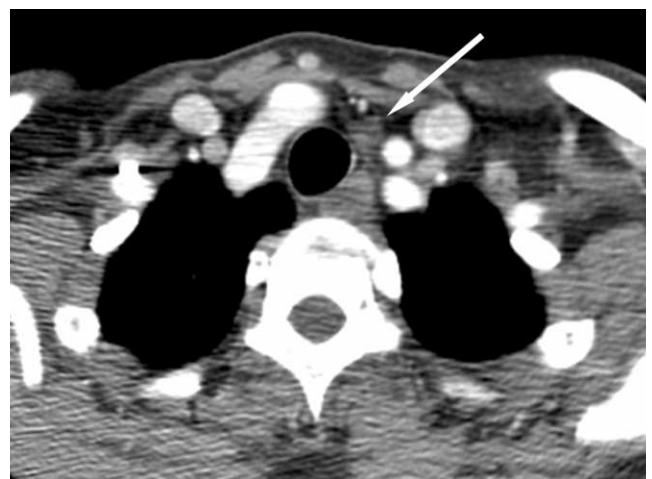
A 50-year-old woman with papillary thyroid cancer in the right lobe of the thyroid gland. A CT demonstrates a lymphadenopathy (arrow) in the left level VI, which is regarded to be positive when applying size criteria, and negative when applying morphologic criteria. The formal report suggested possible lymph node metastasis, but pathologic exam revealed a reactive lymphadenopathy.
